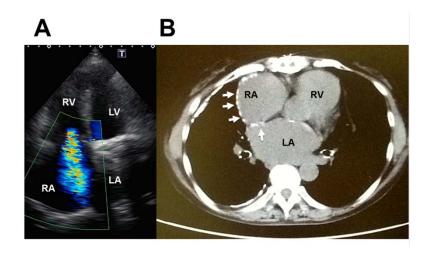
A: Apical 4-chamber views showing dilatation of right atrium, and moderate-severe tricuspid regurgitation by color Doppler. RV: Right ventricle, RA: Right atrium, LV: Left ventricle, LA: Left atrium. B: A chest CT revealed scattered calcification in the wall of the atria (arrows). There was no thickening of the pericardium. RV: Right ventricle, RA: Right atrium, LA: Left atrium
